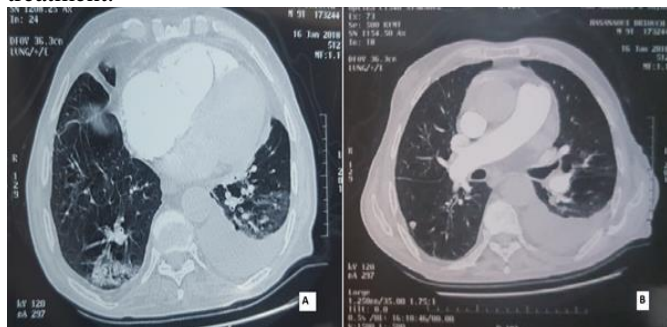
control thoracic angio-CT: no right atrial thrombus (A) a distal pulmonary embolism with pulmonary infarct and moderate left pleural effusion (B)
